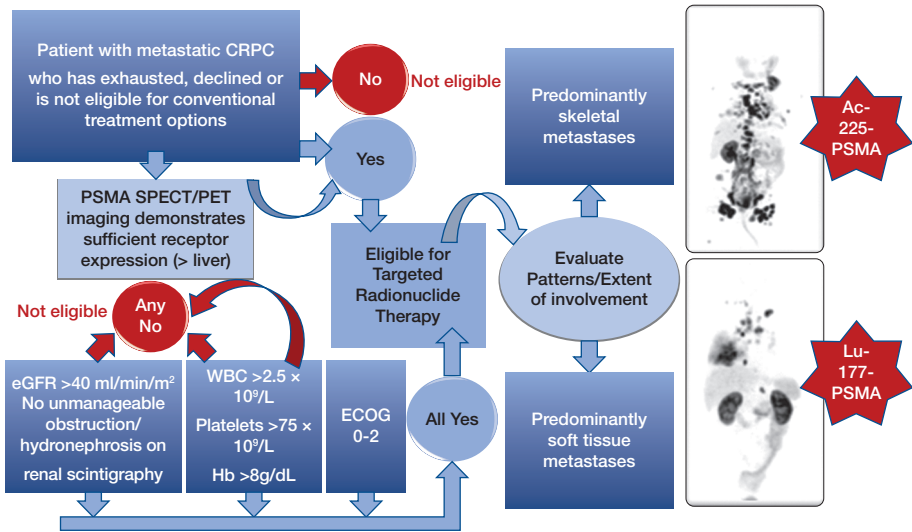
Patient selection for targeted radionuclide therapy. Eligibility evaluation for PSMA radioligand therapy includes demonstrating the presence of sufficient PSMA overexpression on imaging as well as ensuring adequate renal function, bone marrow reserves and ECOG of less than 2. Diffuse skeletal metastases are better suited to treatment with ^{225}Ac -PSMA as opposed to the presence of predominantly soft tissue metastases that is better suited to treatment with ^{177}Lu -PSMA.
